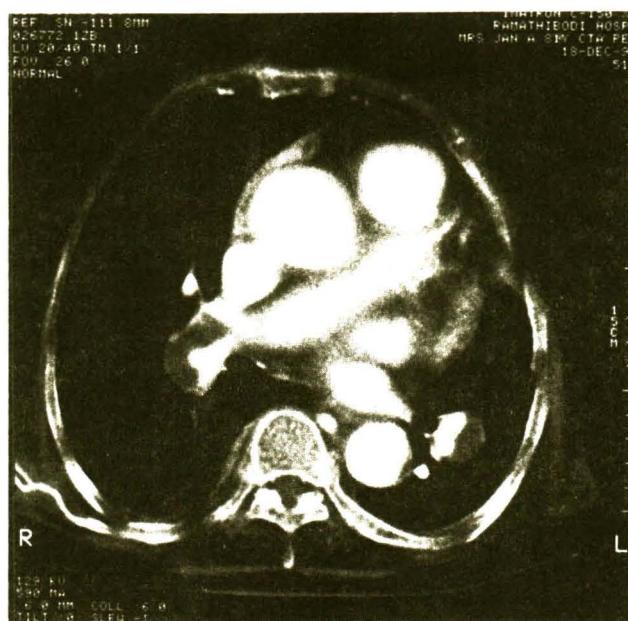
Electron beam CT of pulmonary artery with thrombus in the right pulmonary trunk.
